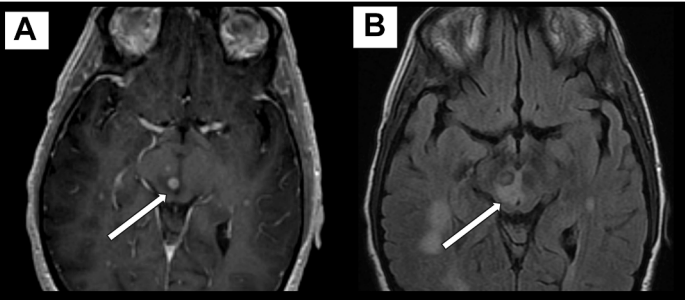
Mid-brain metastasis. Axial T1-weighted imaging (A) showing enhancing right midbrain lesion (white arrow) and axial FLAIR imaging (B) showing surrounding edema (white arrow) involving areas of pupillary light reflex processing.
